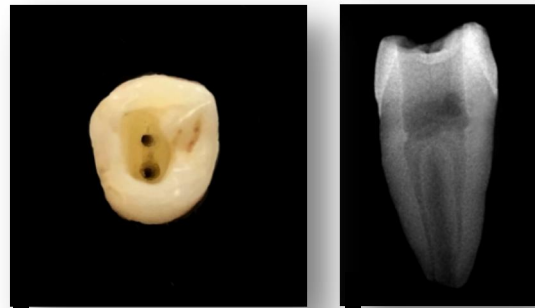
and 1B. Show the traditional access cavity preparation and the corresponding radiograph.
